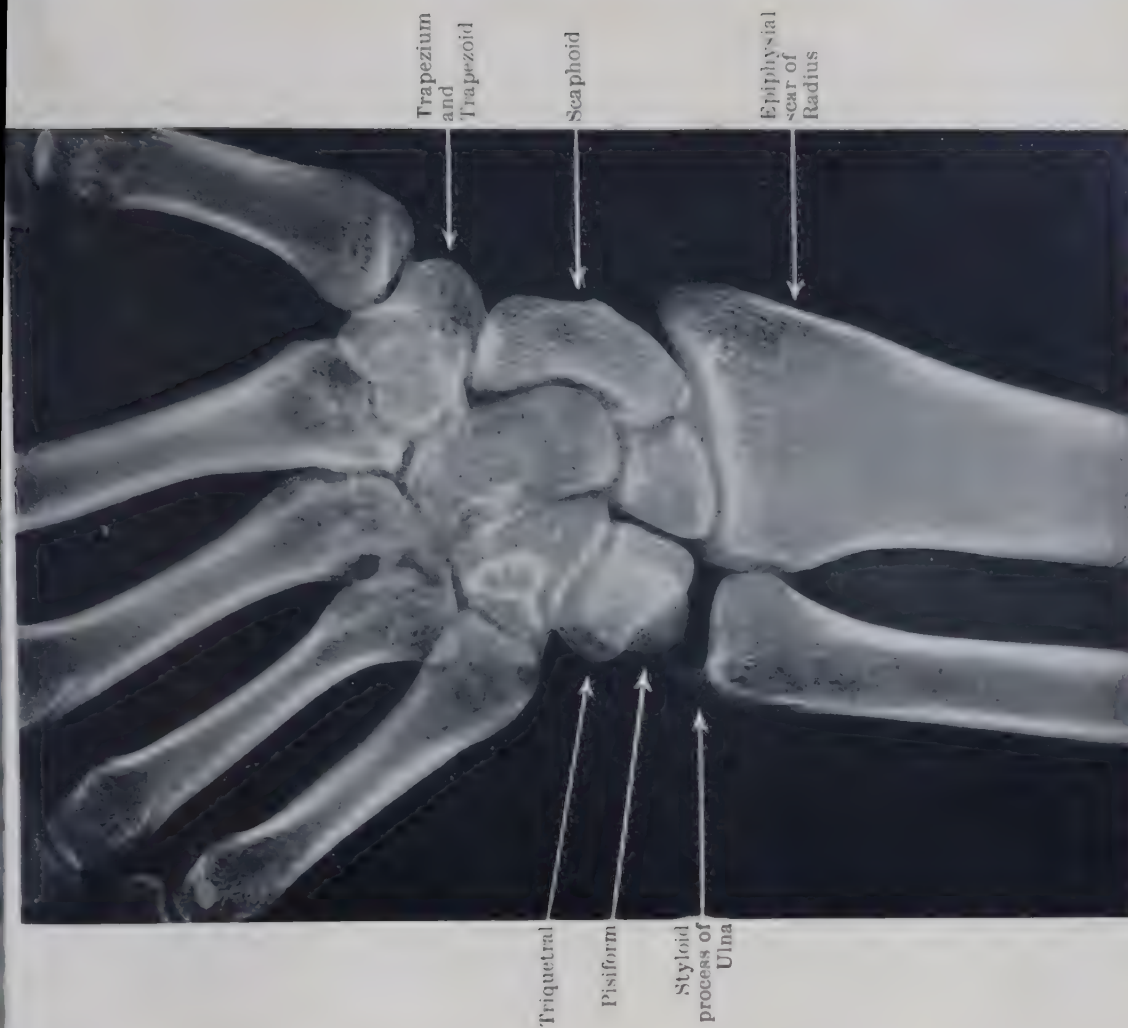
RADIOGRAPH OF THE SAME WRIST IN EXTREME ULNAR FLEXION (ADDUCTION) AT THE RADIO-CARPAL JOINT.
